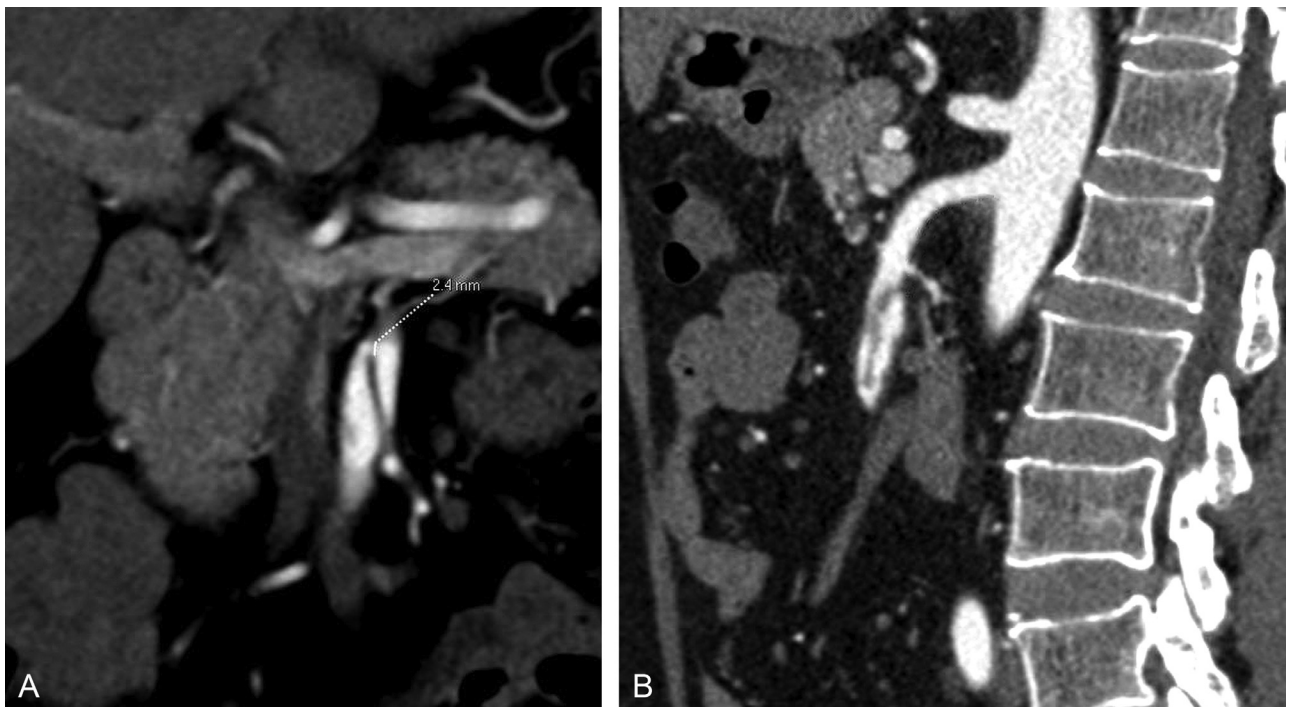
Computed Tomography at 6 months after discharge: (A) the diameter of the entry point was 2.4 mm, (b) SMA viewed sagittally.
